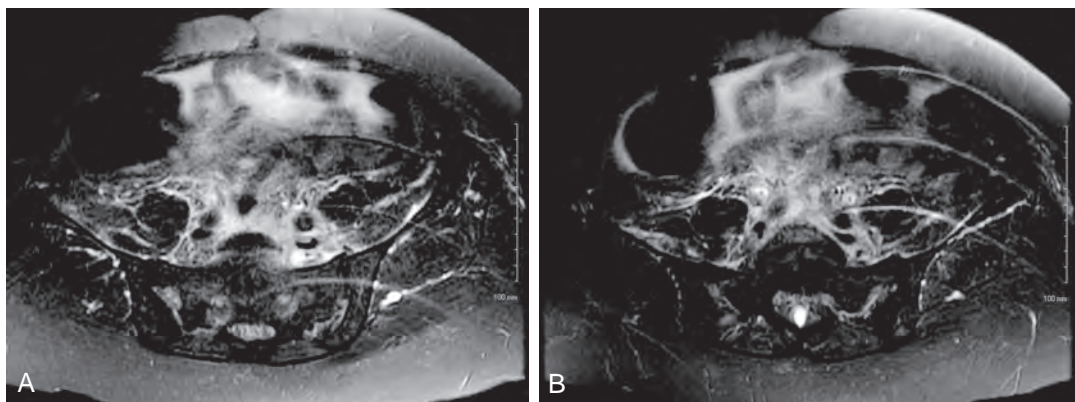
A, T2-weighted magnetic resonance image of a symptomatic patient demonstrating retroperitoneal fibrosis with enhancement and thus active disease. B, Same patient after 1 month of medical therapy; note the decrease in enhancement on this corroborative T2-weighted image.
